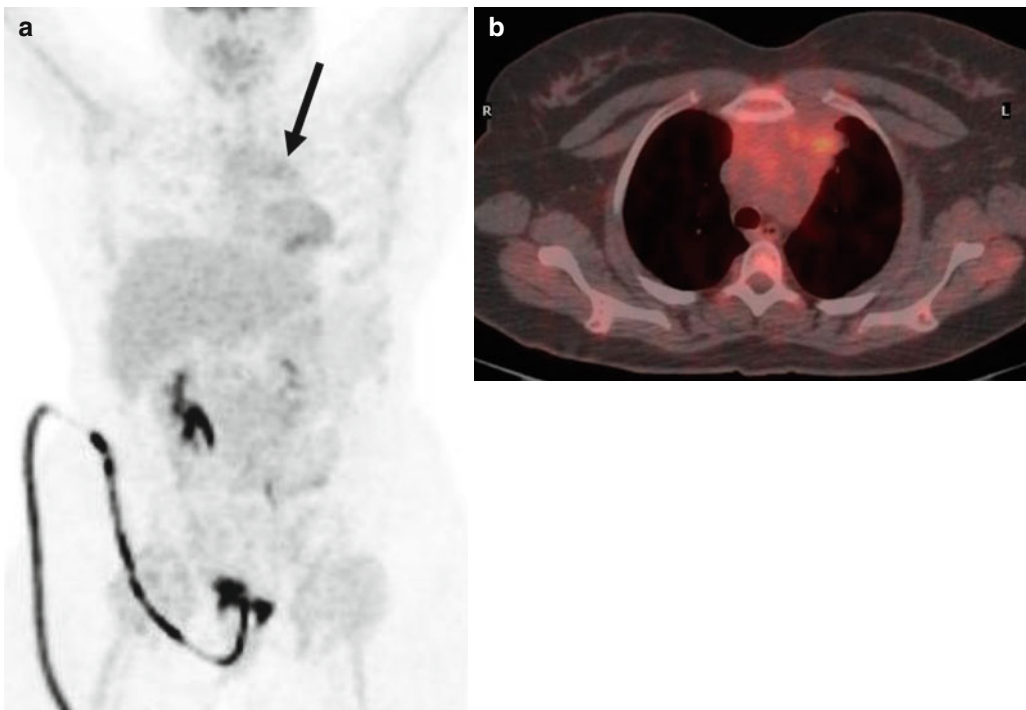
(a, b) MIP-PET and fused PET/CT restaging after immunochemotherapy: moderate 18FDG uptake in the residual mediastinal mass exceeding the uptake of the mediastinal pool but not that of the liver parenchyma (arrow in the MIP image) (D5-PS score 3)
